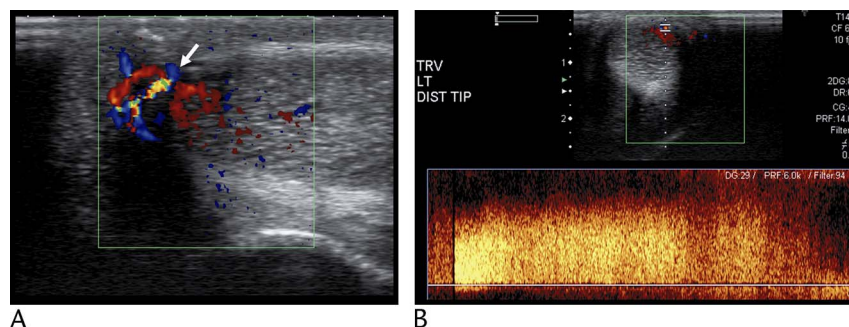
A 27-year-old man with painless persistent erection after recent penile injury from bull riding. The longitudinal color flow sonogram of the penis shows an area of color flow aliasing (arrow) within the left corpus cavernosum near the tip of the penis. B, Spectral waveform demonstrates a high-velocity, low-resistance blood flow pattern confirming the presence of a fistula. Images used with permission from the *Journal of Ultrasound in Medicine*.
